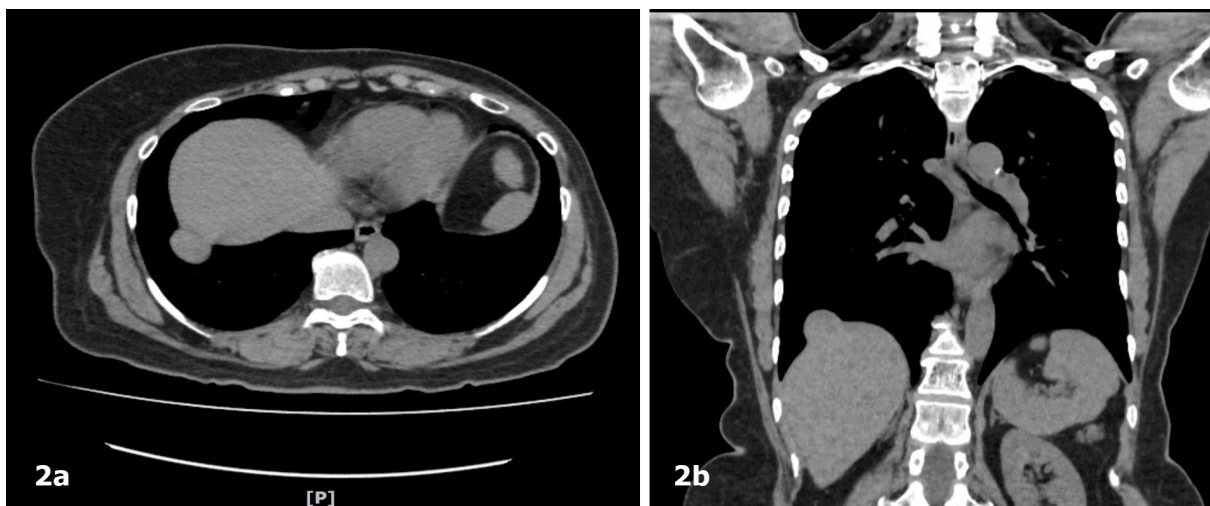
a) Computed chest tomography in axial view soft tissue window revealing pedunculated liver lesion arising from segment VII, b) Segment VII SDL on coronal image soft tissue window of CT Thorax.
